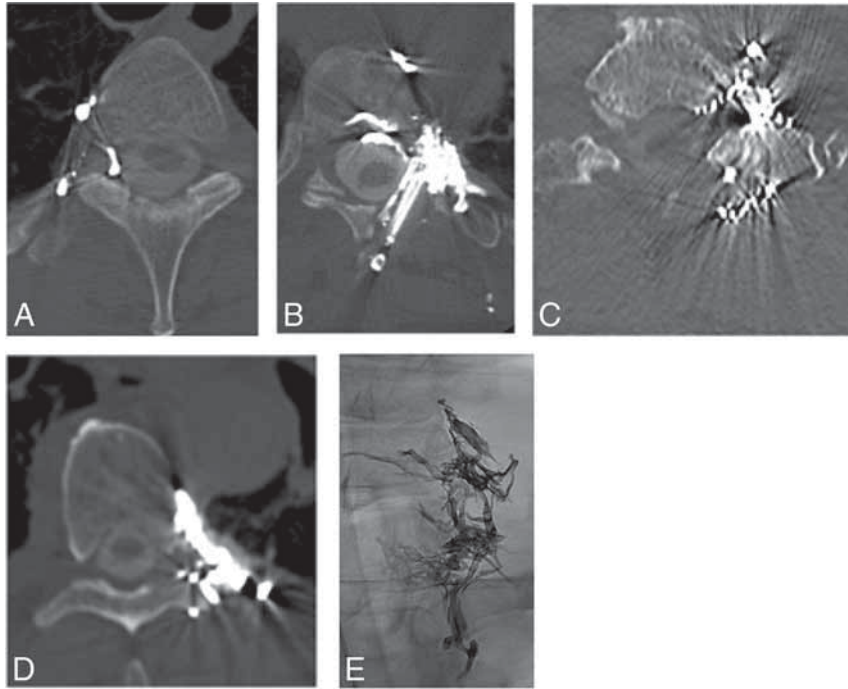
Post-transvenous embolization CT scans (A–D) and an anterior-posterior radiograph (E) showing Onyx within the neural foramen in 4 patients (A–C and E) and just outside the neural foramen in 1 patient (D). The CT scan in B shows the results after surgical clip ligation following transvenous embolization.
